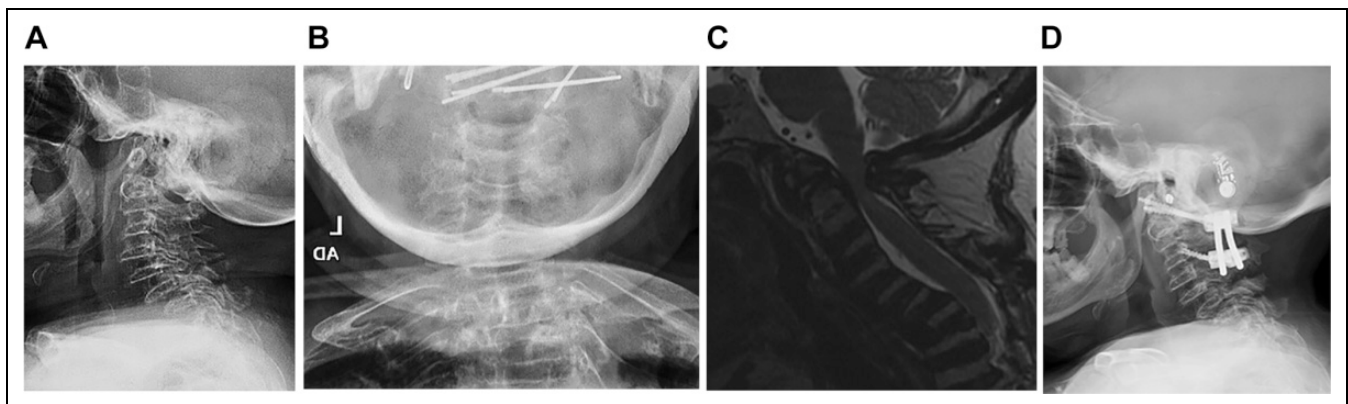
64F with spondyloepiphyseal dysplasia with signs and symptoms consistent with cervical myelopathy. Imaging consistent with os odontoides and atlantoaxial instability (Figure 1A-, 1B, 1C, flexion/extension views not shown). Patient underwent suboccipital and C1 decompression and C1-C3 posterior fusion. C2 was not instrumented due to a high riding vertebral artery on the left and a diminutive pedicle and pars on the right. In accordance with the preoperative plan, the patient was kept intubated postoperatively and extubated on POD1. A CT chest was performed on POD5 showing a large central pulmonary embolus within the right main pulmonary artery. An IVC filter was placed the same day, and the patient was started on therapeutic enoxaparin the next day. On POD8, the patient was started on antibiotics given dysuria and increased frequency in the setting of a positive urine culture. Two-year follow up shows no hardware displacement and a solid fusion (Figure 1D and E).
